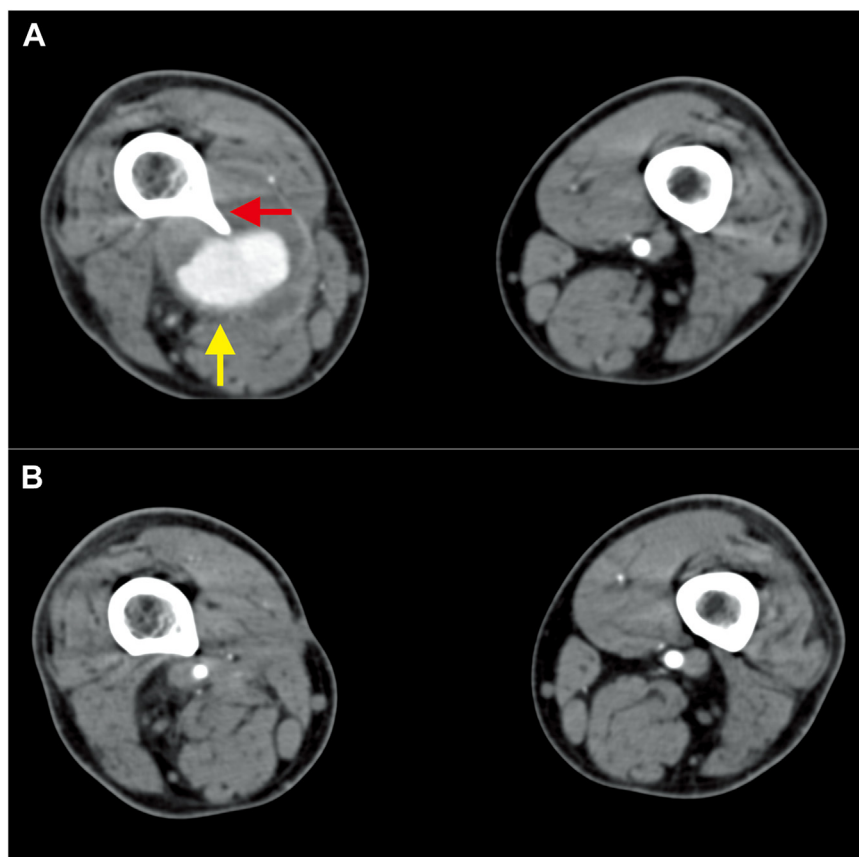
A, Computed tomography angiography (CTA) showing an exostosis (red arrow) located at the distal femur with a popliteal artery pseudoaneurysm (yellow arrow). B, Axial images obtained 6 months after surgery showing no recurrence of the exostosis and complete resolution of the pseudoaneurysm.
